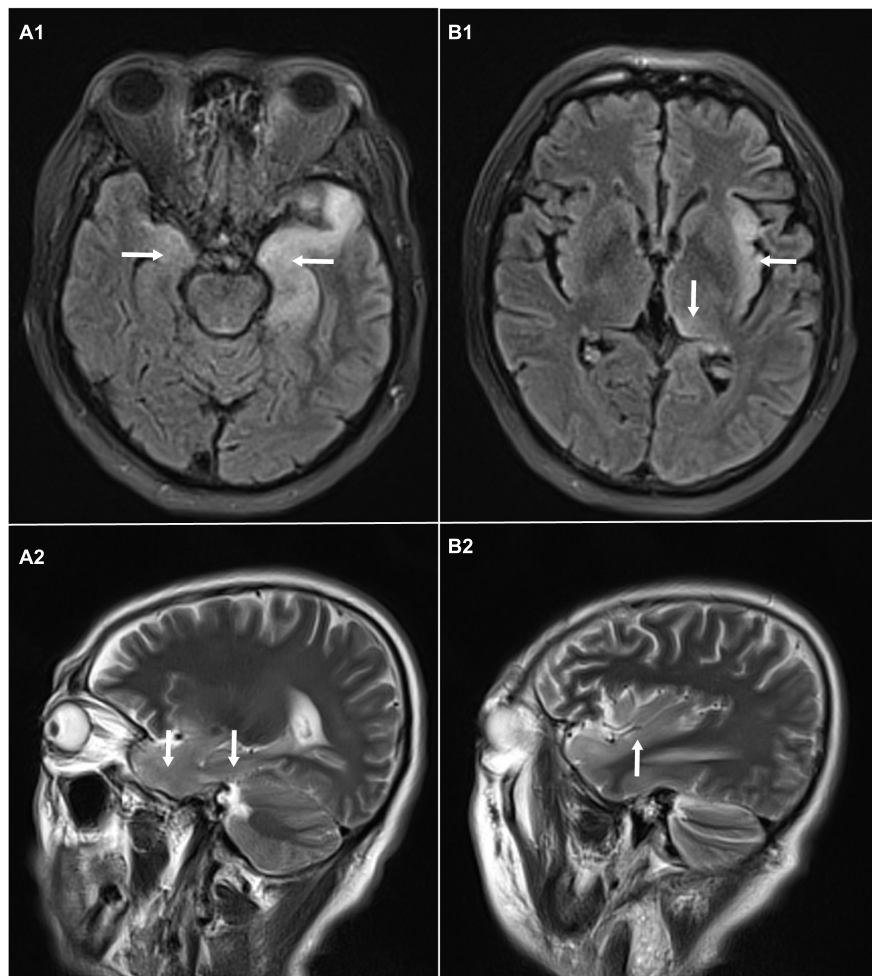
Brain magnetic resonance imaging: abnormal signal of T2-weighted images and fluid-attenuated inversion recovery images (T2/FLAIR) in the left thalamus, temporal lobe, insular lobe and bilateral hippocampus. (A1) Axial MRI showed high signals on FLAIR in the left temporal lobe and bilateral hippocampus. (A2) Sagittal MRI showed high signals on T2 in the temporal lobe and hippocampus. (B1) Axial MRI showed high signals on FLAIR in left thalamus, and insular lobe. (B2) Sagittal MRI showed high signals on T2 in left insular lobe.
